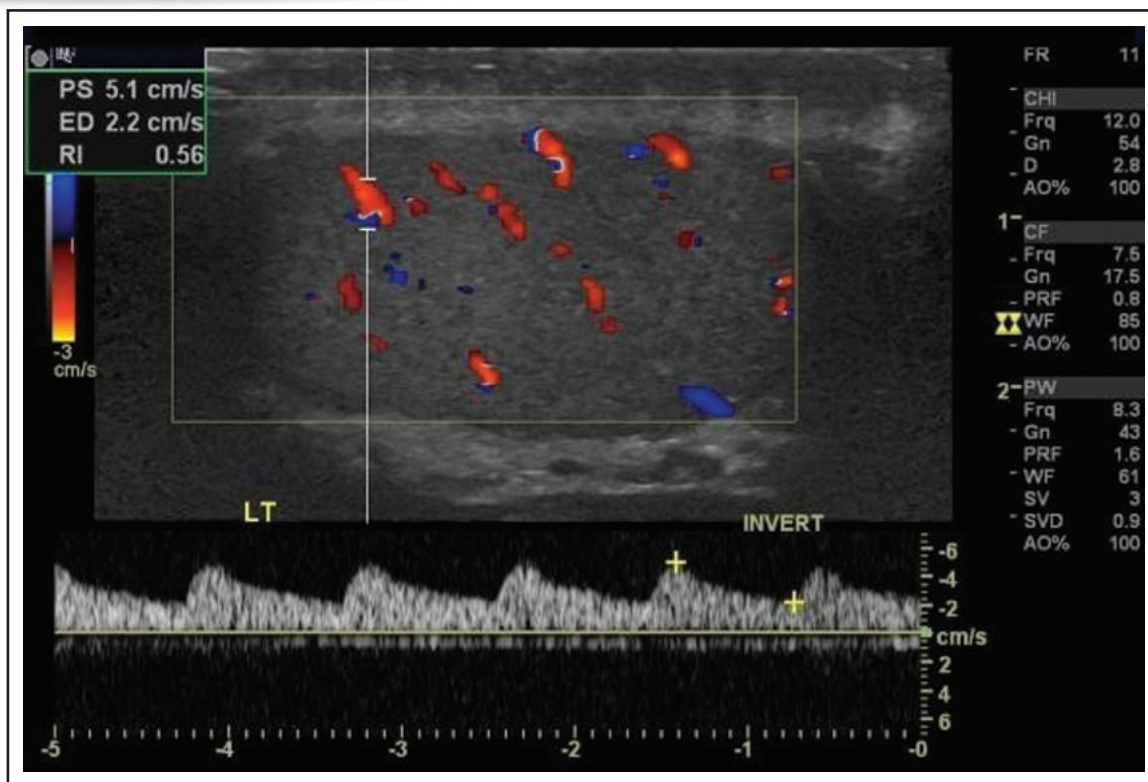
Normal spectral Doppler waveforms. Normal perfusion, low resistance waveforms with an RI of 0.56.
